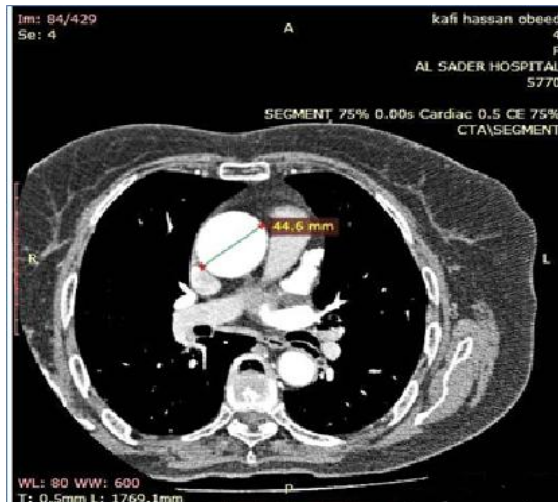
Aneurysm of ascending aorta incidentally found in 57-year-old man who was referred for coronary CT angiography for evaluation of coronary arteries .
